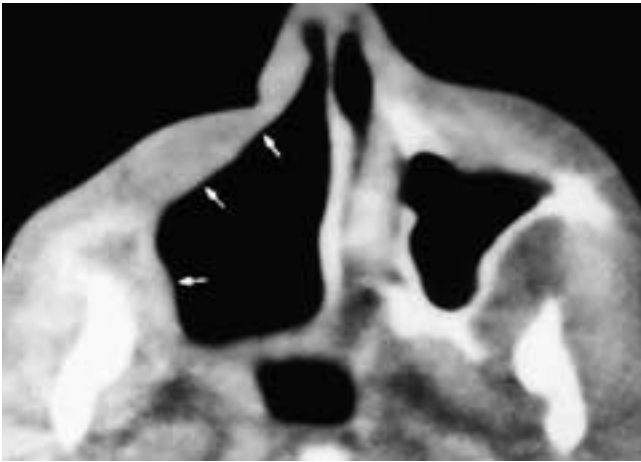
Axial CT scan shows the normal postoperative appearance of a right total maxillectomy. The postoperative cavity is smoothly lined (*arrows*). The pterygoid plates were resected in this patient.
